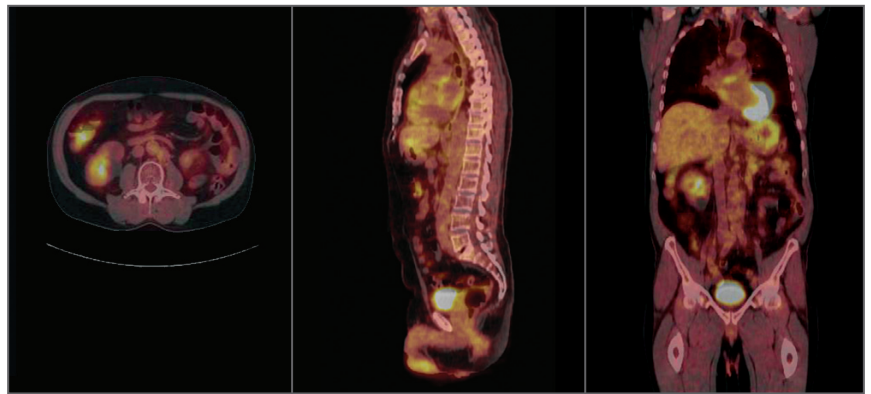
PET-CT scans obtained 14 months after CyberKnife treatment demonstrating a continued reduction in the FDG uptake in the region of the confluent left para-aortic adenopathy.
